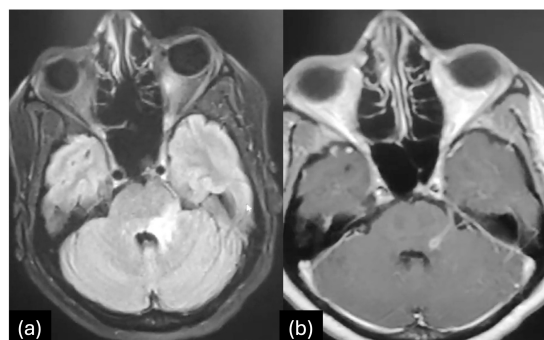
(a) Axial fluid-attenuated inversion recovery (FLAIR) image shows FLAIR hyperintensity along the left trigeminal nerve nucleus in its pontine course. (b) An axial T1W image shows enhancement along the left trigeminal nerve and its nucleus. This patient had herpetic trigeminal neuritis and presented with neuralgia. Image courtesy: Dr. Safwan Ahmad (DM-Neurology).
